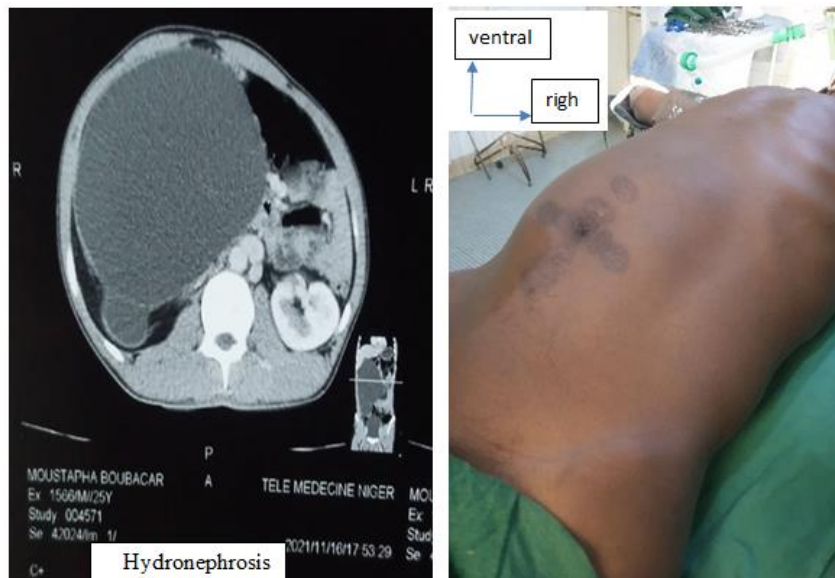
Computed tomography: Destruction of the renal parenchyma by a pyelic lithiasis
